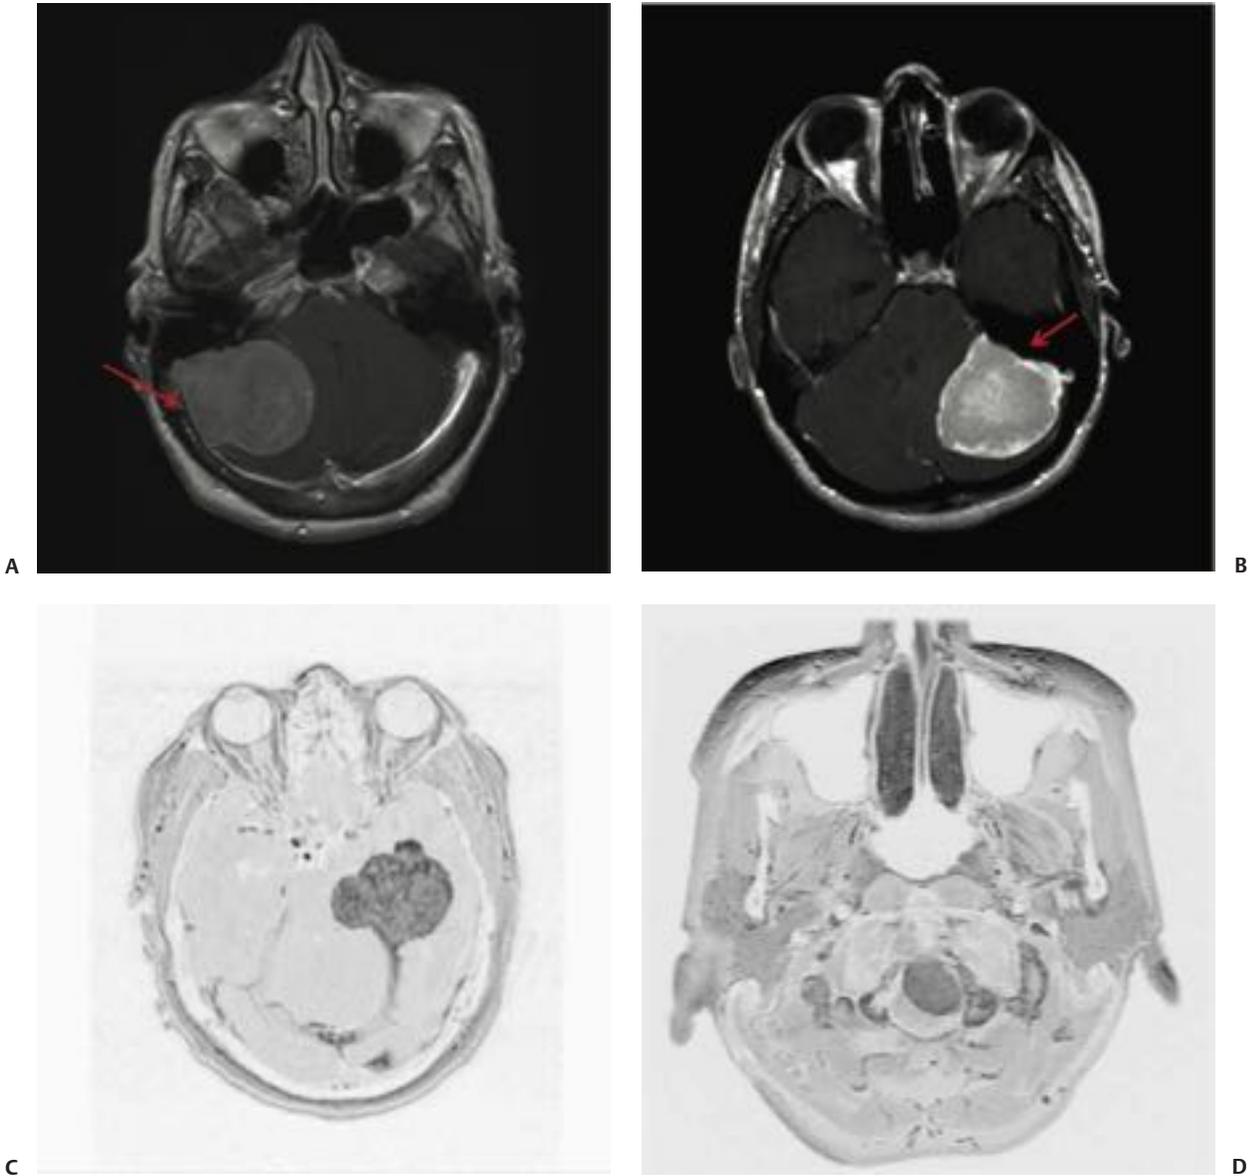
A comparison of the radiographic appearance of (A) cerebellar convexity meningiomas with (B) meningiomas of the posterior petrous face, (C) the tentorium, and (D) the foramen magnum.
